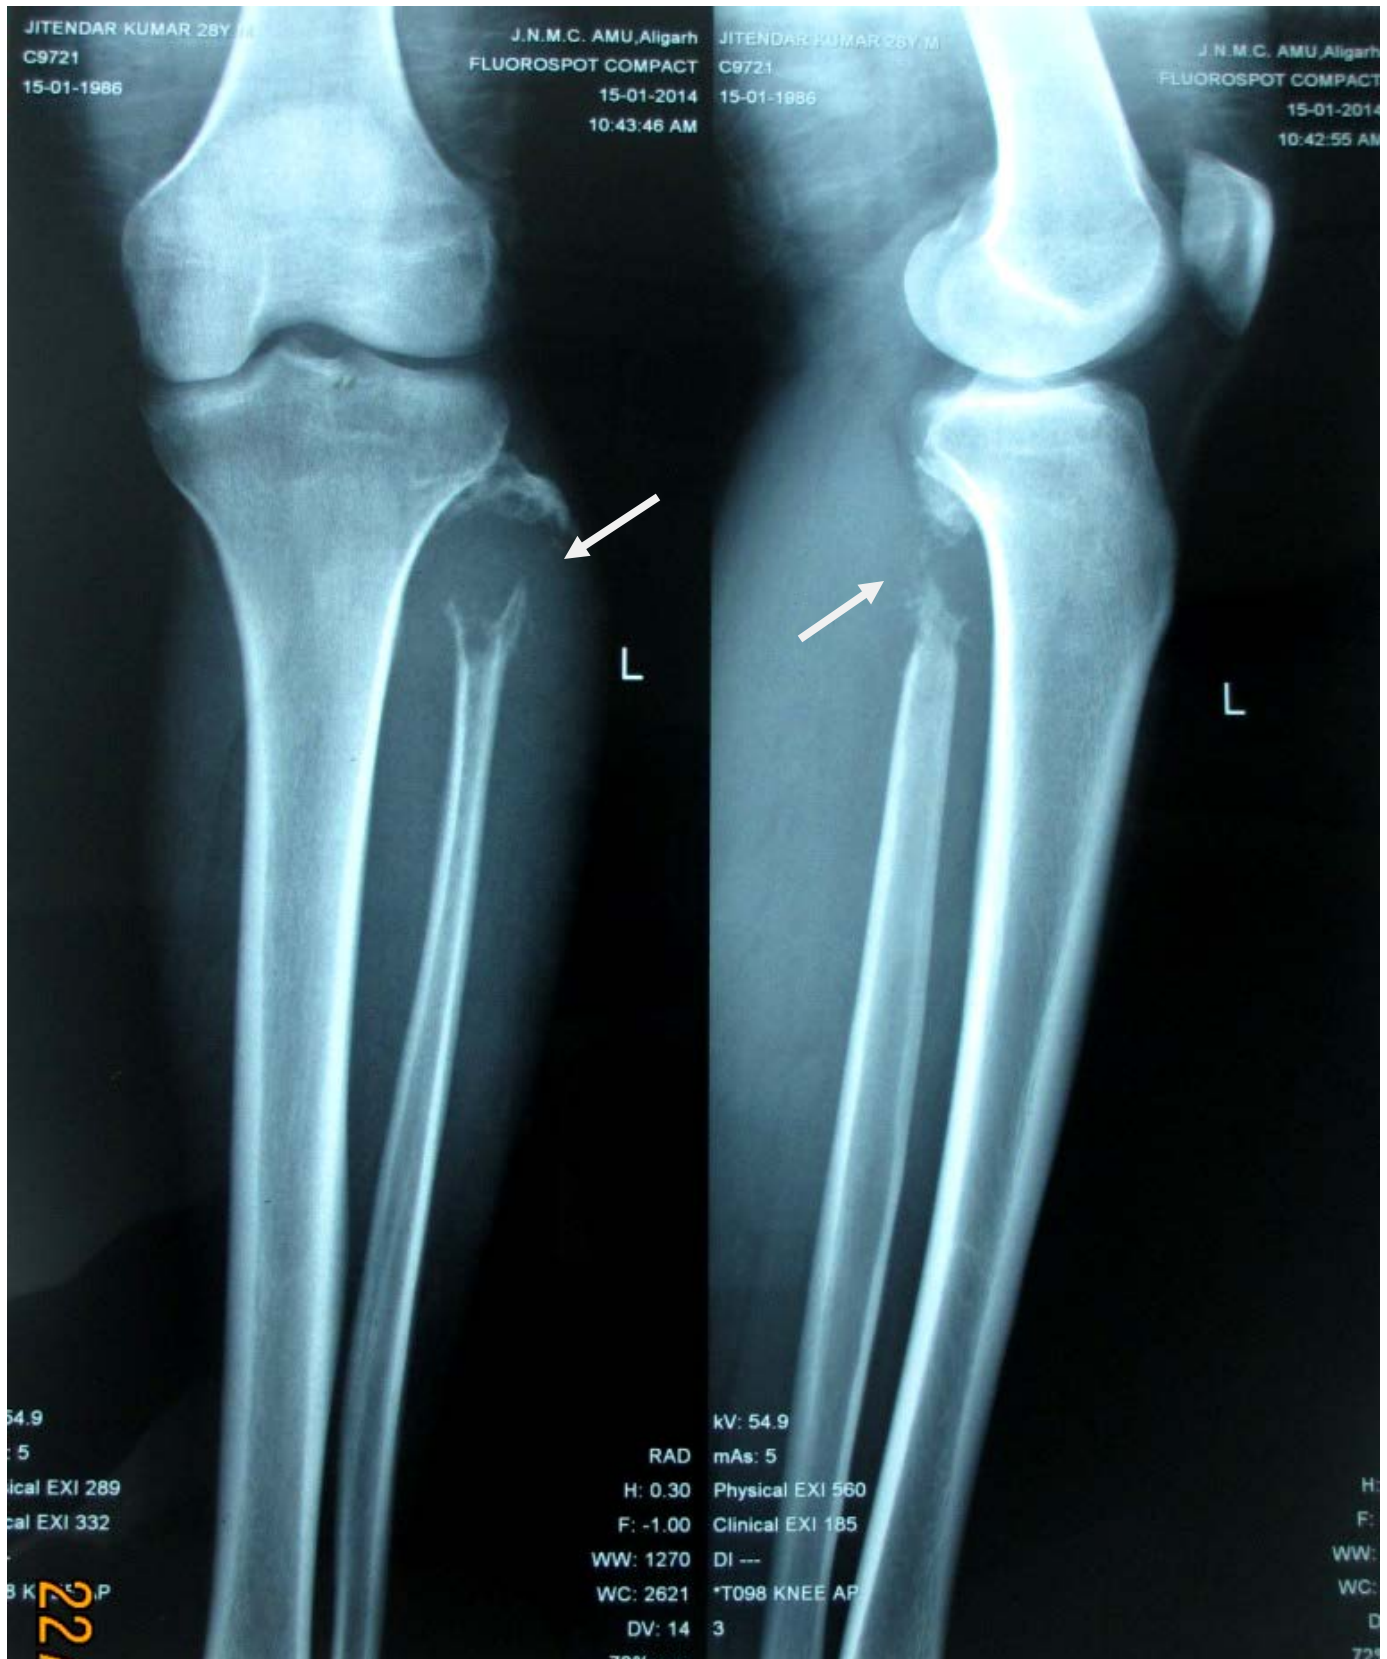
Radiograph of the left leg showing osteolytic lesion at the proximal end of the left fibula.
